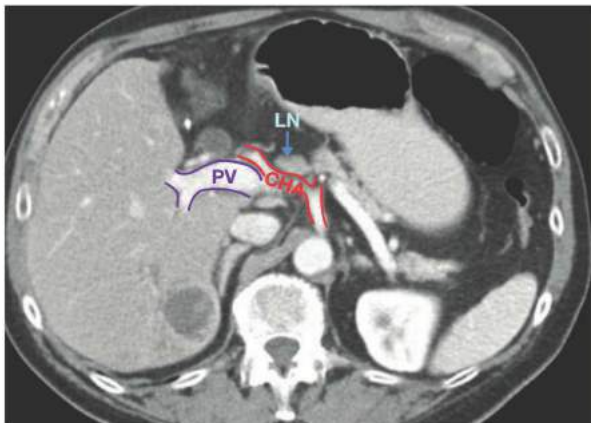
• Axial CT showing an enlarged lymph node (LN) abutting the celiac bifurcation. A hepatocellular carcinoma can be seen in segment 6. Also labeled are the portal vein (PV) and the common hepatic artery (CHA).
